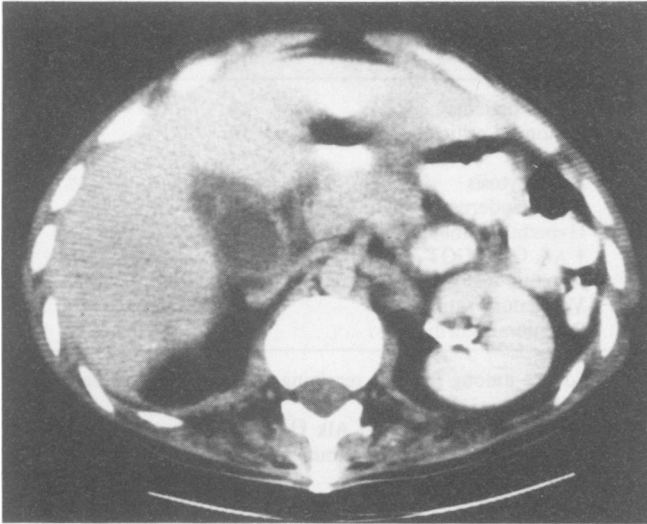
CT scan demonstrating thickened gallbladder wall.
